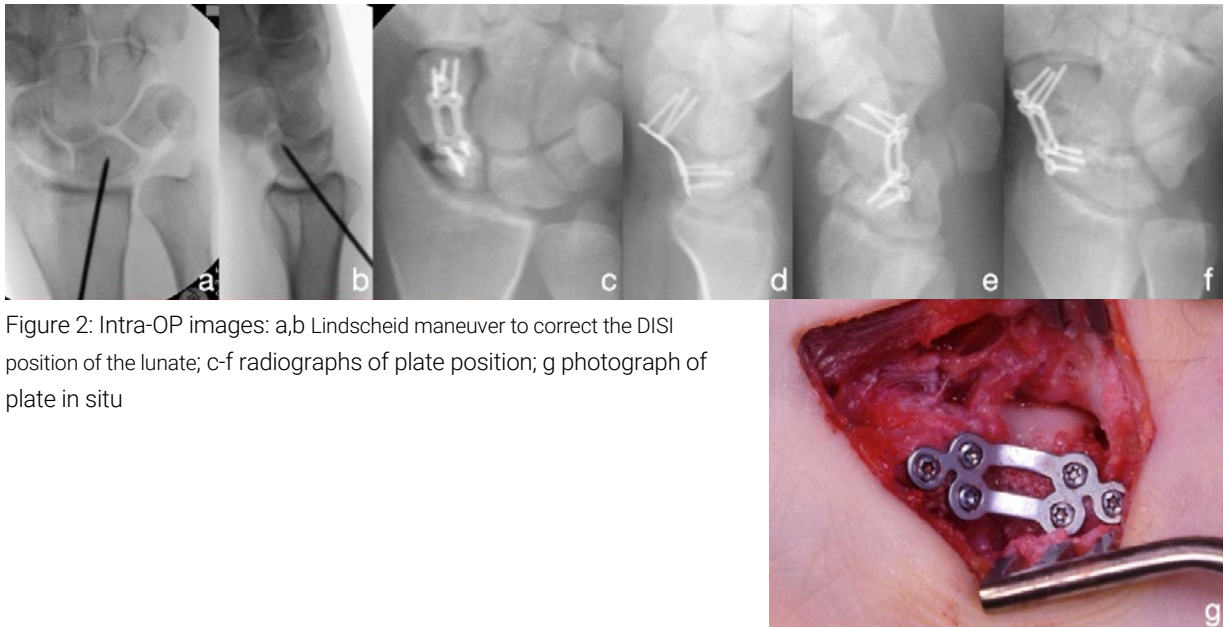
Intra-OP images: a,b Linscheid maneuver to correct the DISI position of the lunate; c-f radiographs of plate position; g photograph of plate in situ
